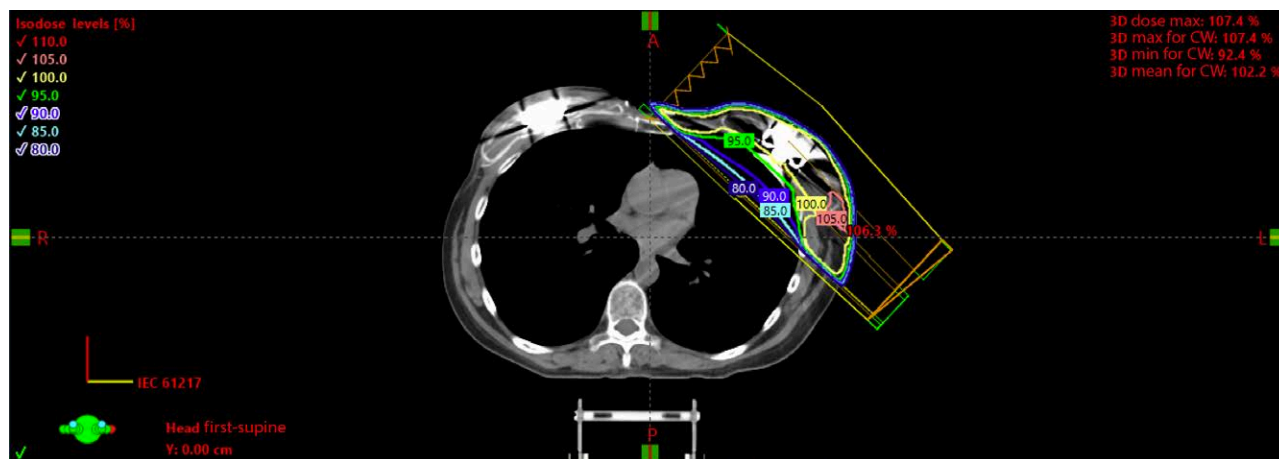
Typical 3D CT and radiation plan on ARIA.
